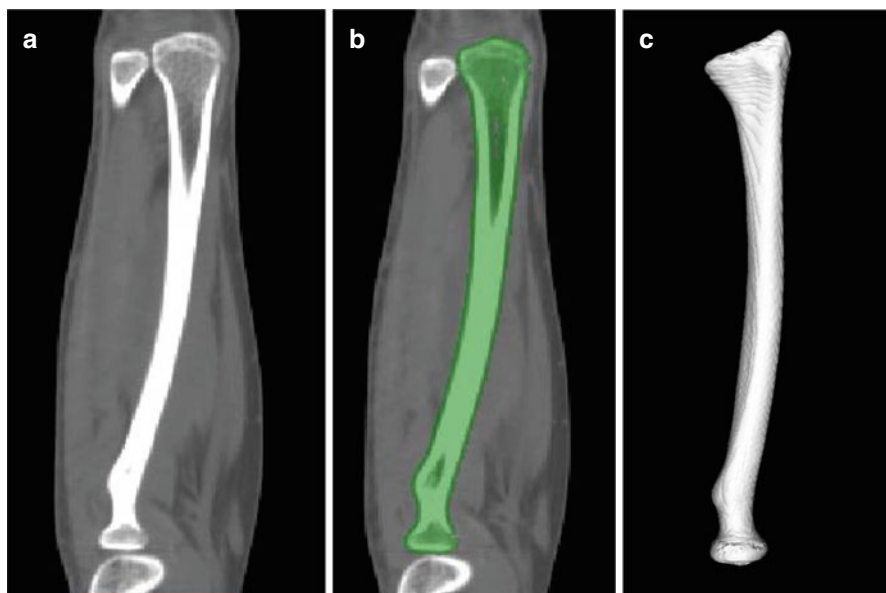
3D bone surface models of the entire bilateral radius and ulna are created from 1.25-mm CT data. CT slice (a), segmentation of the radius (b) and 3D bone surface model of the radius (c)
